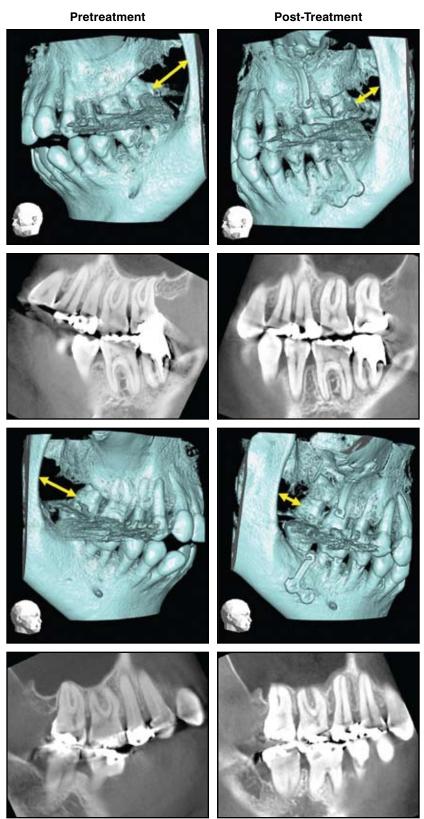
Pre- and post-treatment CBCT images show maxillary molar intrusion and distalization after treatment with SAS.
